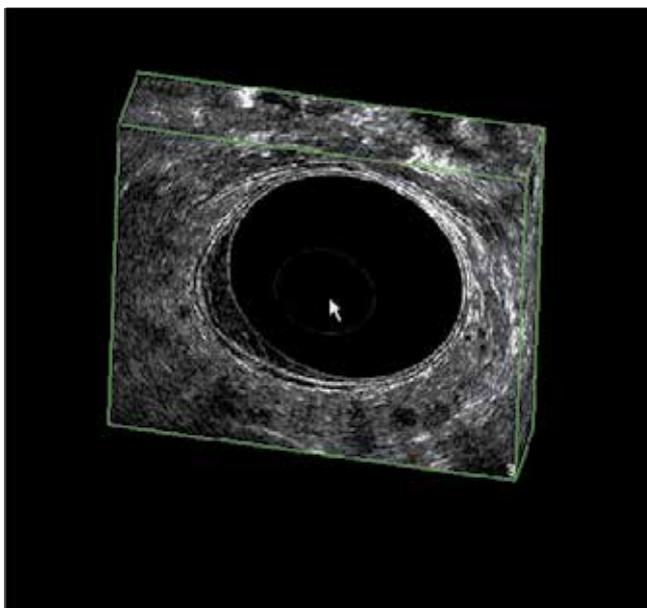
3D endorectal ultrasound showing a rectal mass without disruption of any of the rectal wall's layers.
